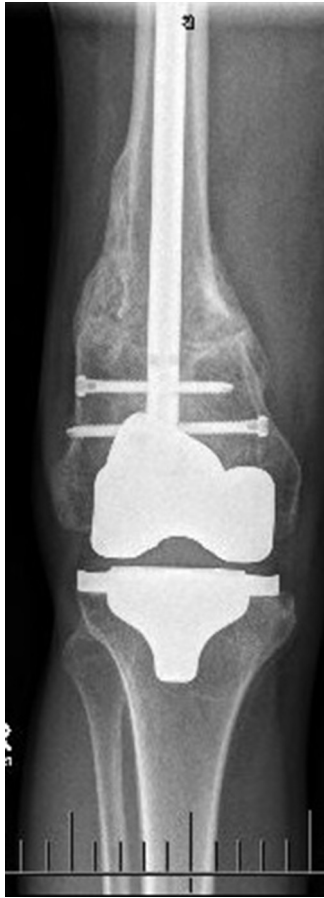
Anteroposterior knee radiograph taken at 6 months postoperatively.
